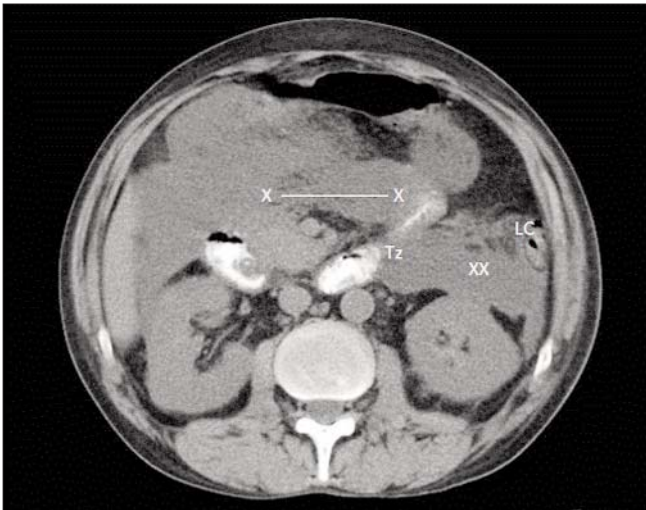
CT scan (native) - Septic necrosis in omental bursa and left anterior prerenal and left retrocolic areas. X-X-omental bursa collection; XX - left prerenal and retrocolic suppuration; LC- left colic angle; Tz- Treitz angle
